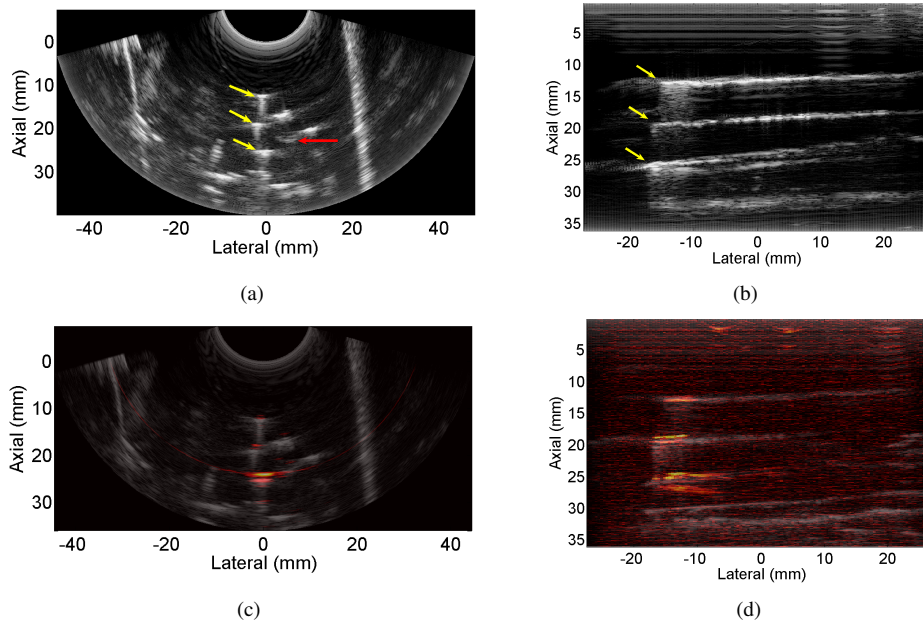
B-mode ultrasound images acquired with (a) curvilinear and (b) linear arrays of the transrectal ultrasound probe. Yellow arrows point to the three implanted seeds, and the red arrow shows the location of the fiber. Seed #1 is the uppermost seed in each image. (c,d) Corresponding photoacoustic images overlaid on the B-mode images in a yellow-red color scale. The dynamic range of the B-mode images and the linear and curvilinear PA images was adjusted to 50, 35, and 20 dB, respectively.
